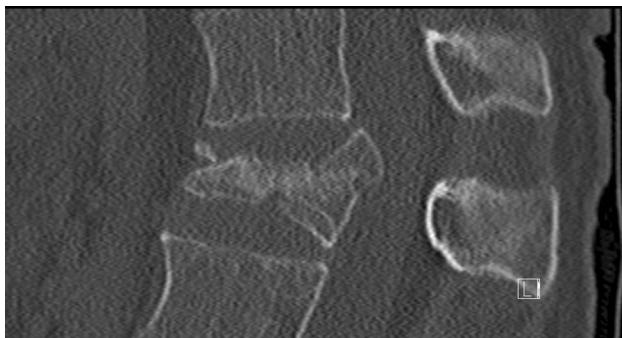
The CT scan showed an AO A3.3-burst fracture of the L1
